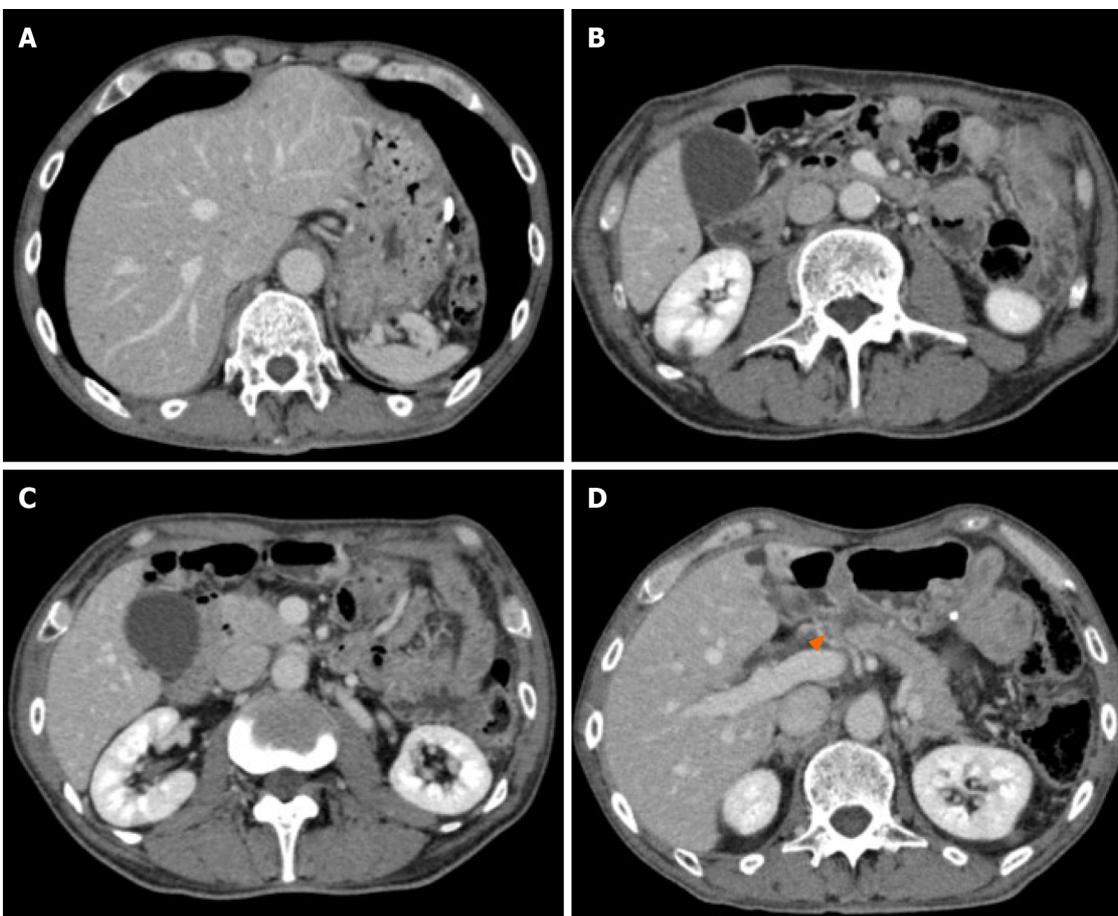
Computed tomography findings after neoadjuvant chemotherapy. A: #3 lymph node (LN) became smaller and could not be detected; B: #4d LN became smaller and could not be detected; C: #6 LN became smaller and could not be detected; D: #8a LN became smaller (orange triangle; 14.0 mm × 13.4 mm × 9.2 mm × 7.0 mm).
